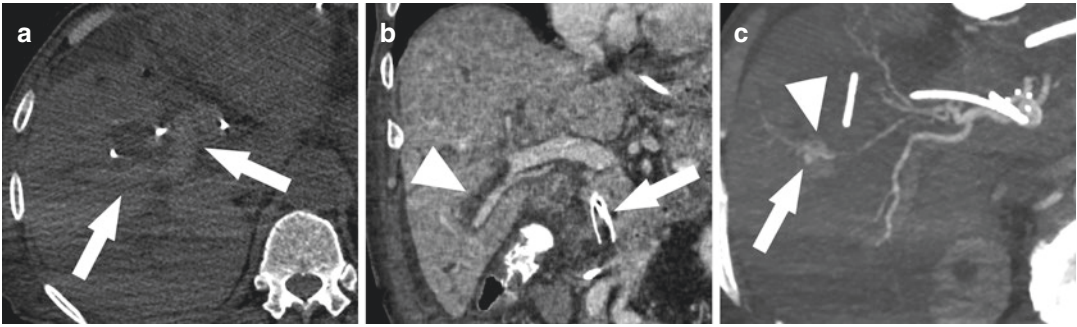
Hemobilia in a 67-year-old man with gallbladder carcinoma infiltrating the extrahepatic biliary ducts and biliary stent, presenting with anaemia after percutaneous transhepatic biliary catheter placement. (a) Axial non-enhanced CT image shows hyperattenuating material in massively dilated intrahepatic biliary ducts (arrows) suggestive of acute haemorrhage. (b) Coronal contrast enhanced CT image shows marked intrahepatic biliary
